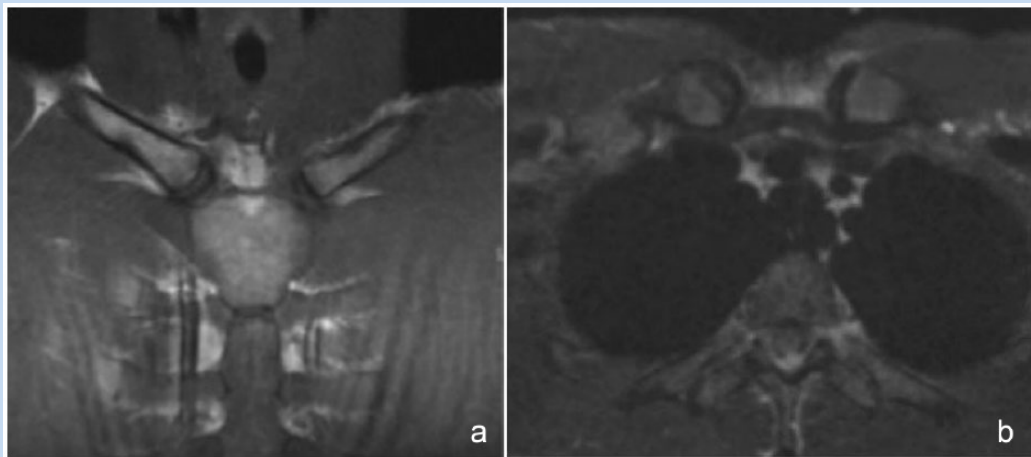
MRI of the sternoclavicular joints taken prior to injury in 2009 demonstrating reduction and symmetry of the bilateral sternoclavicular joints. (a) Coronal view, (b) axial view.
